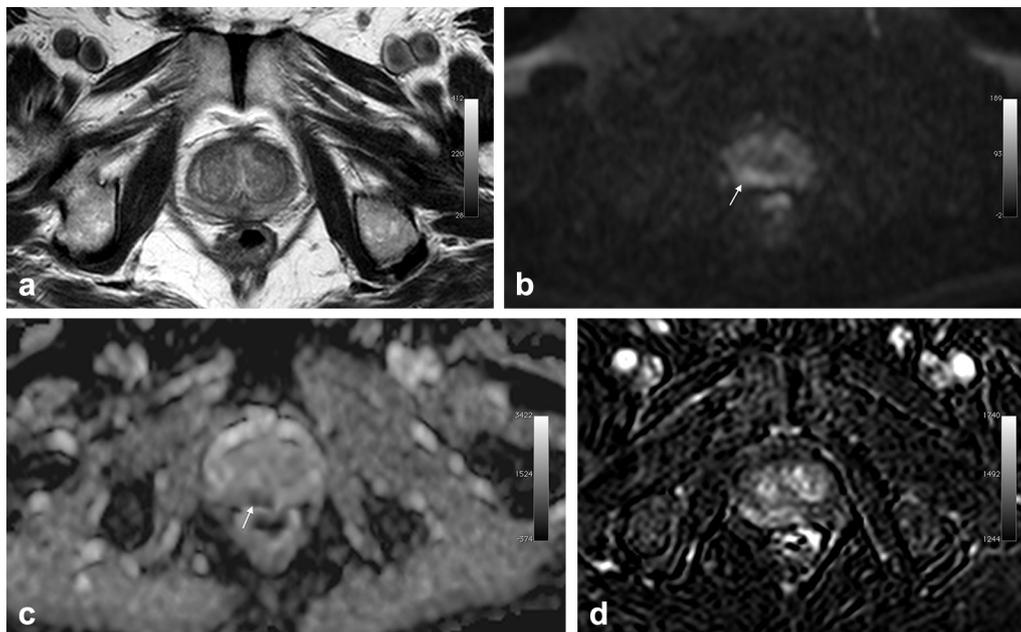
MR imaging of the prostate 6 months after chemoembolization in the same patient shown in [Figure 1](#). The PCa decreased in size and is depicted only with diffusion imaging. (a) PCa is not seen on axial T2-weighted image. (b) Hyperintense with diffusion restriction (b1400). Arrow indicates PCa. (c) Hypointense on apparent diffusion coefficient map. Arrow indicates PCa. (d) PCa is not seen with perfusion imaging. PSA at 6-month follow-up decreased to 0.5 ng/mL.
